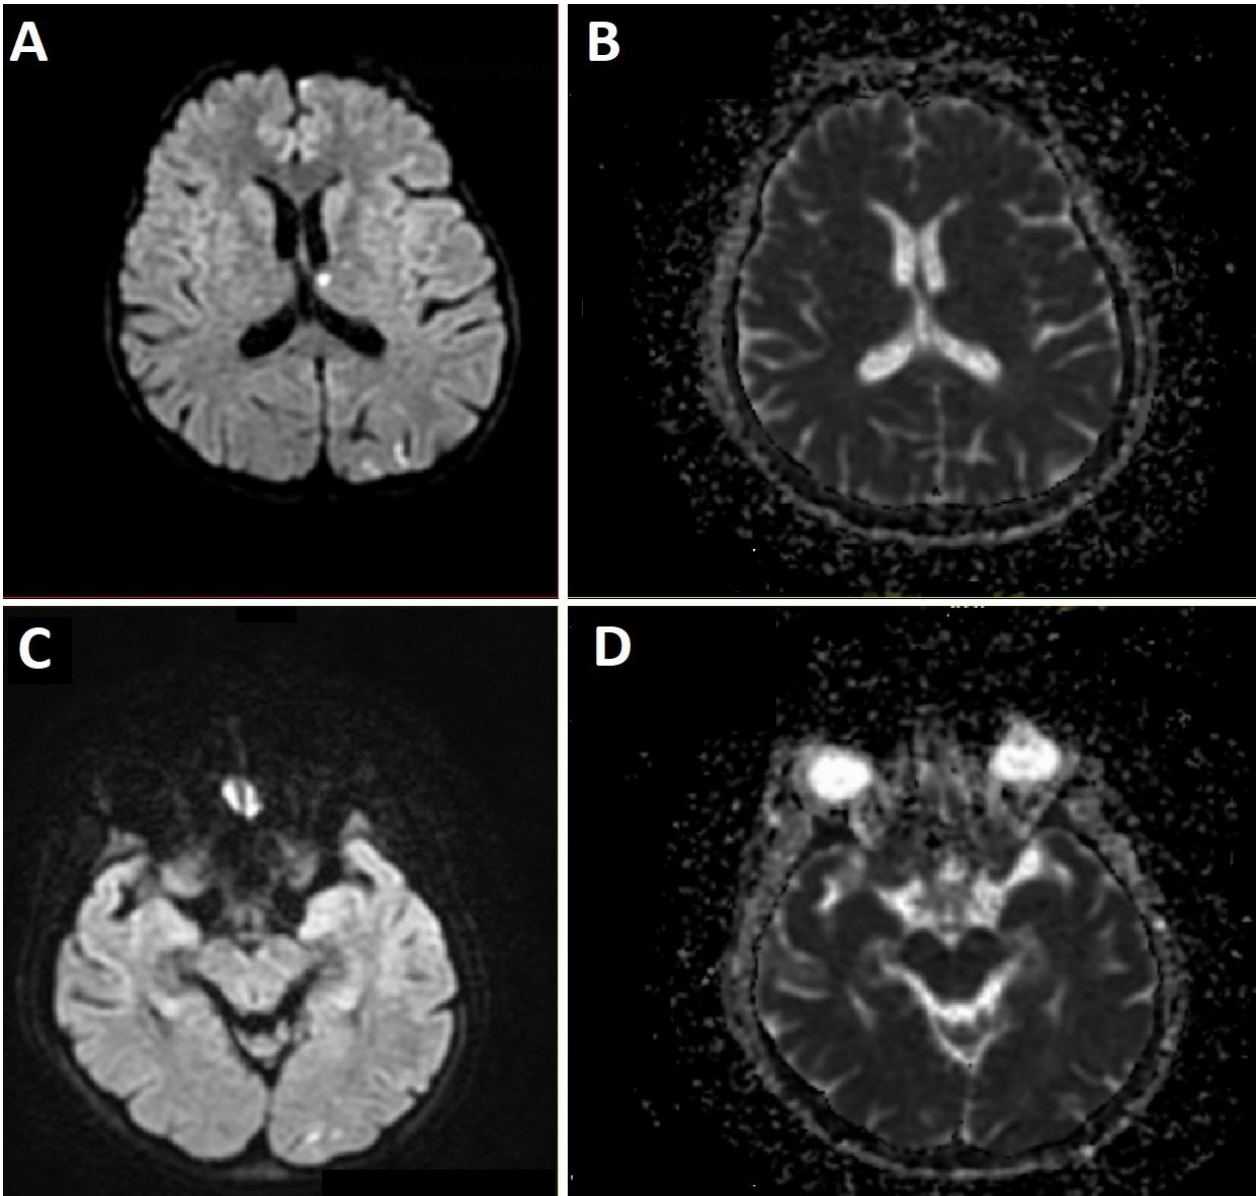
In diffusion MRI, a lesion compatible with an acute infarct is observed, A) hyperintense in the left thalamic and left occipital cortical areas in the b1000 sequence, B) hypointense in the ADC sequence, C) hyperintense in the left occipital region in the b1000 sequence, and D) hypointense in the ADC sequence.
